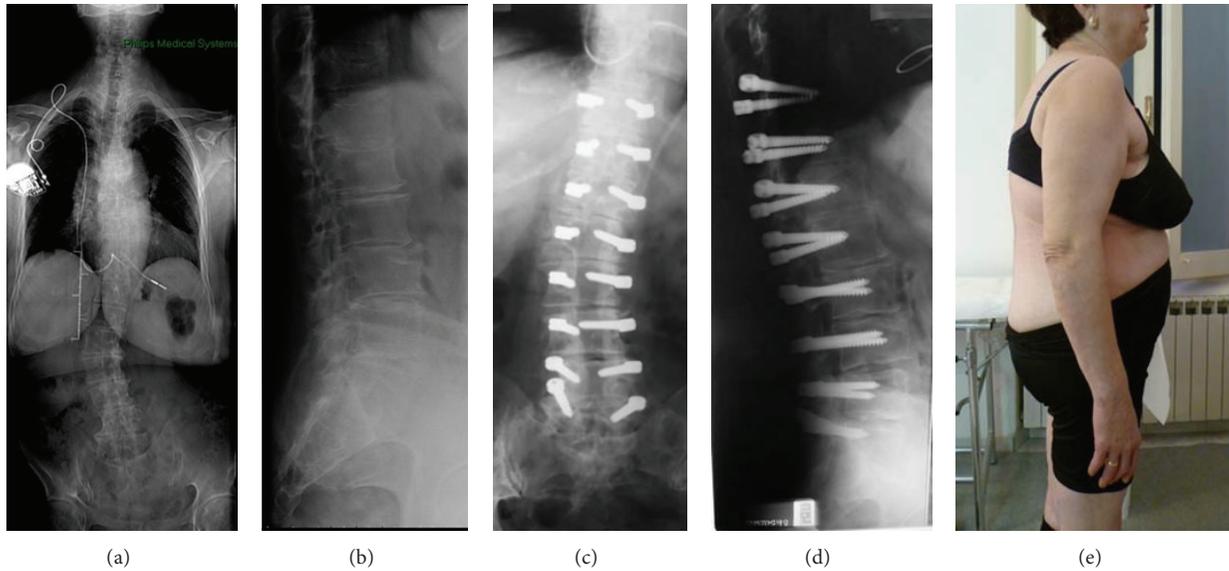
A 71-year-old woman. Degenerative lumbar scoliosis associated with stenosis of the vertebral canal: good sagittal balance ((a), (b)). Treatment: T11-S1 dynamic fixation and decompressive laminectomy. Six-year and 9 months postoperative radiographs showing stable scoliosis correction with maintained sagittal balance ((c), (d), and (e)).
